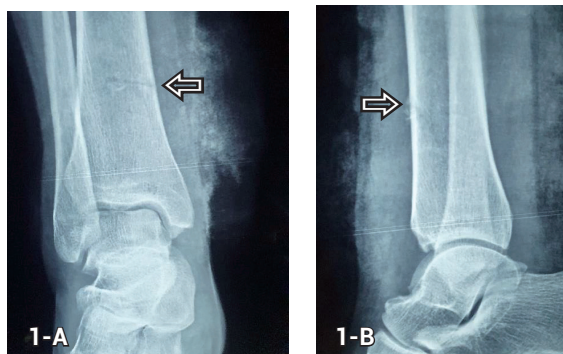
A and 1-B: AP (1-A) and lateral (1-B) X-ray views of the distal tibia. Arrow points to the bony cut injury.
